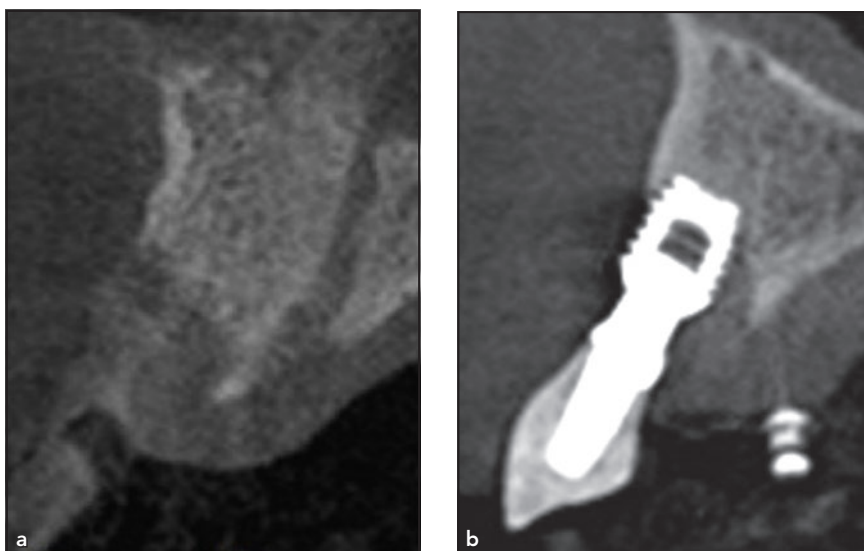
Preoperative CBCT images of the (a) edentulous tooth 11 site (FDI tooth numbering system) and (b) the condemned implant at the tooth 12 site. The buccal bone plate was absent in both areas.
